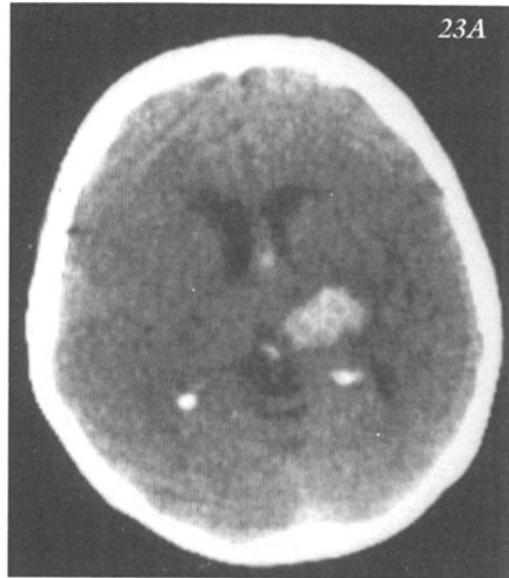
A) Acute hemorrhage left thalamus on CT Scan of a 72 year old woman with clinical findings of severe hypertension (210/130), dense right sided hemiparesis and sensory deficits plus fluent aphasia. B) Old cystic cavity (arrow) on CT Scan, 2.5 years later. She had significant sensory symptoms and cortical sensory deficits in right arm and leg, ataxia of gait, intention tremor of right hand and leg and occasional choreiform movements of the right hand.
